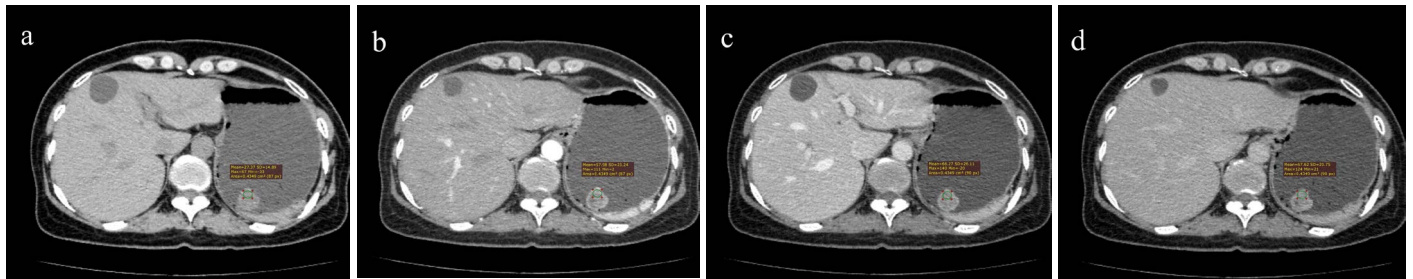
A CT scan (a) shows a nodular soft tissue density lesion on the posterior wall of the gastric fundus protruding into the stomach. It shows uneven density, has fairly clear boundaries, and with irregular edges. The CT scans with three-phase enhancements (b,c,d) exhibit progressively moderate and uneven enhancement of the lesions.
